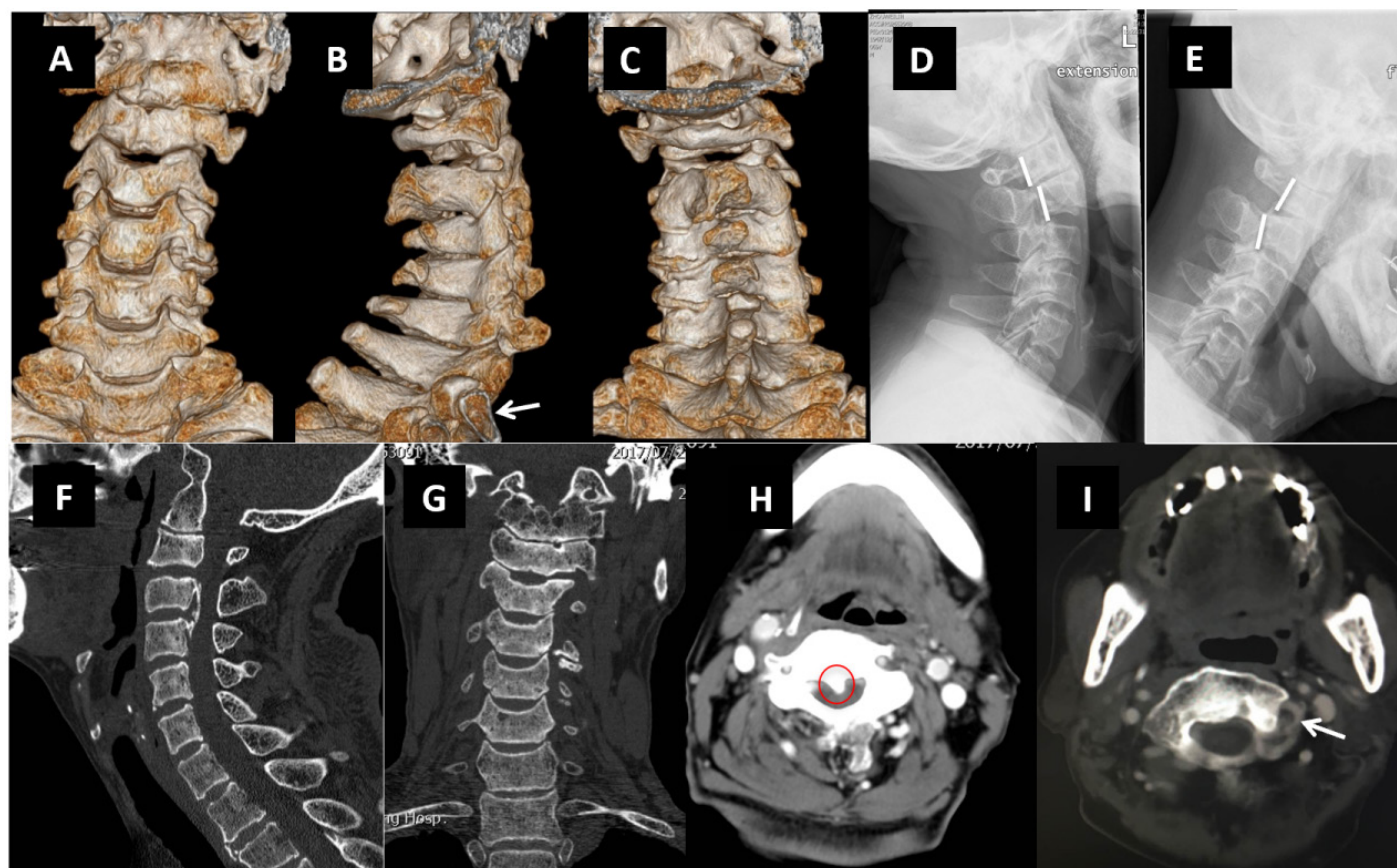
Three-dimensional CT reconstruction of the cervical spine. (A) Frontal view of the cervical spine showing a normal lower cervical spine and loss of odontoid process at C2. The posterior arch of C2 resembled that of the atlas and the vertebra was connected to C1 via a pseudojoint. C1 was fused to the occipital bone, forming a 16-mm-high bony structure to the foramen magnum; (B) Lateral view showing six cervical spine above T1 and first rib (marked by →); (C) Posterior view of the cervical spine showing that the posterior arches of C2 and C3 resembled those of the atlas and axis, respectively, while the lower cervical spine was normal; (D, E) Extension-flexion radiographs of cervical spine revealing significant misalignment of the posterior margins (solid white lines) of C2 and C3 at the motion segment (horizontal displacement: 7.7 mm; angular displacement: 19.6°); (F) Sagittal CT reconstruction of cervical spine showing OPLL extending from the posterior side of C3 and to the posterosuperior margin of C4, with a maximum thickness of 5.5 mm, causing 43% canal stenosis; (G) Coronal CT reconstruction of cervical spine showing a C1-like bony structure between the occipital condyles, attached to C2 centrally and bilaterally via a pseudojoint; (H) Transverse CT image revealing a sharp ossified spur at the posterior aspect of C3 protruding into the spinal canal, causing spinal compression (red circle); (I) Transverse CT image at the superior margin of C2 posterior arch showing normal morphology of the C2 lateral masses. The vertebral artery traverses the transverse process, courses around the lateral mass, and enters the spinal canal posteriorly. OPLL, ossification of the posterior longitudinal ligament.
